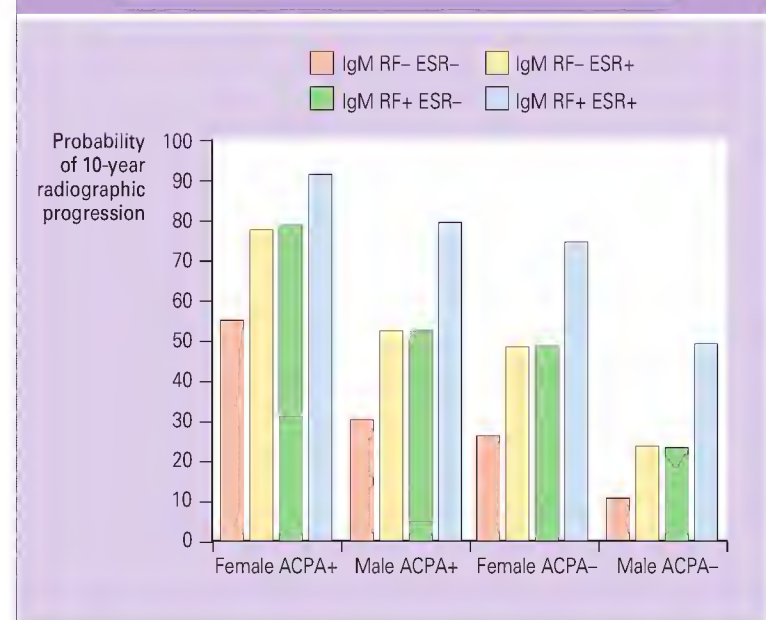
Change in van der Heijde–modified Sharp score of the hands and feet greater than 10 U/10 yr according to different combinations of the independent predictors IgM–rheumatoid factor (IgM-RF), anti-citrullinated peptide antibody (ACPA), and erythrocyte sedimentation rate (ESR) from a logistic regression model. (From Syversen SW, Gaarder PI, Goll GL, et al. High anti-cyclic citrullinated peptide levels and an algorithm of four variables predict radiographic progression in patients with rheumatoid arthritis: results from a 10-year longitudinal study. *Ann Rheum Dis* 2008;67:212-7.)
